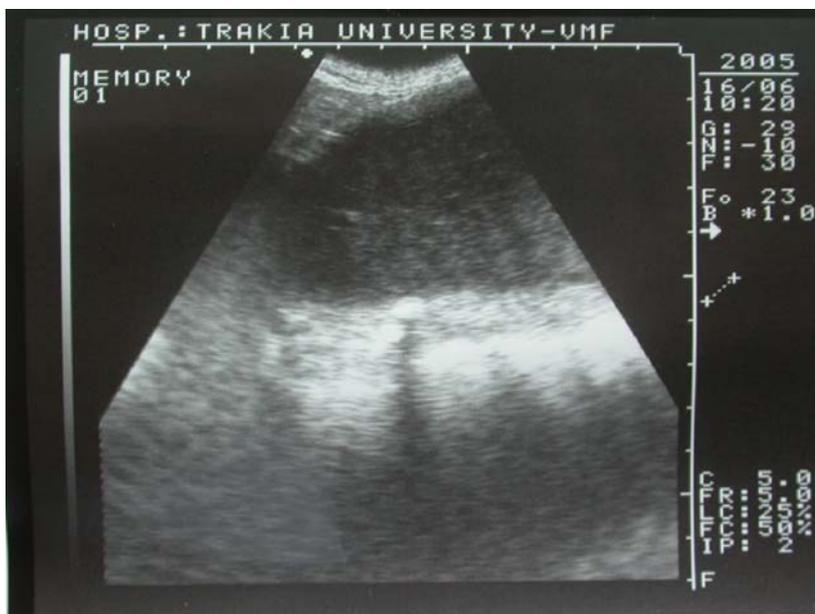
An ultrasound image revealed generally enlarged spleen with multiple areas of hypo- and hyperechogenicity.
